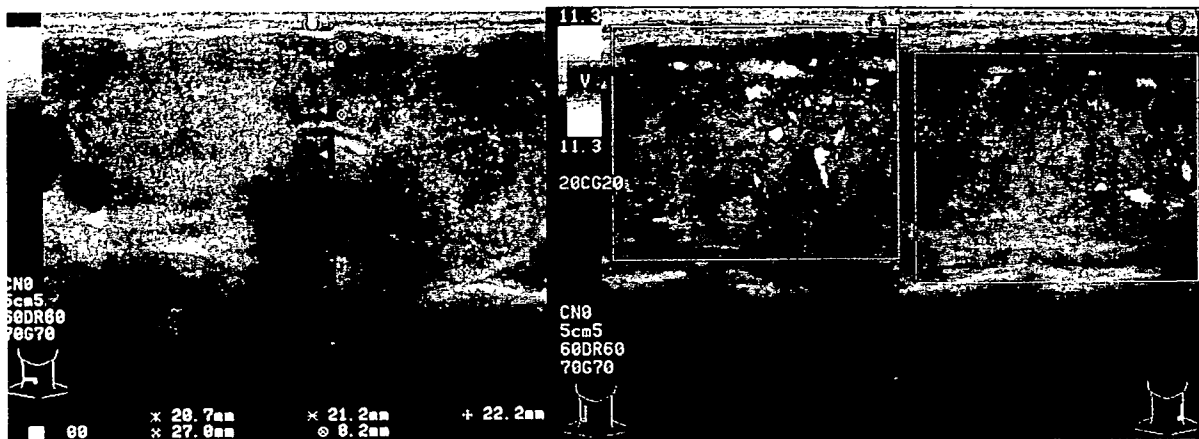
甲状腺エコーではRt; 67.5×20.7×25.5mm, Lt; 58.0×22.2×20.9mm, びまん性に腫大しており, 表面はやや不整, 内部不均一であった. カラー Doppler エコーでは内部血流は増加 (火焰状) していることより Basedow 病と診断.
